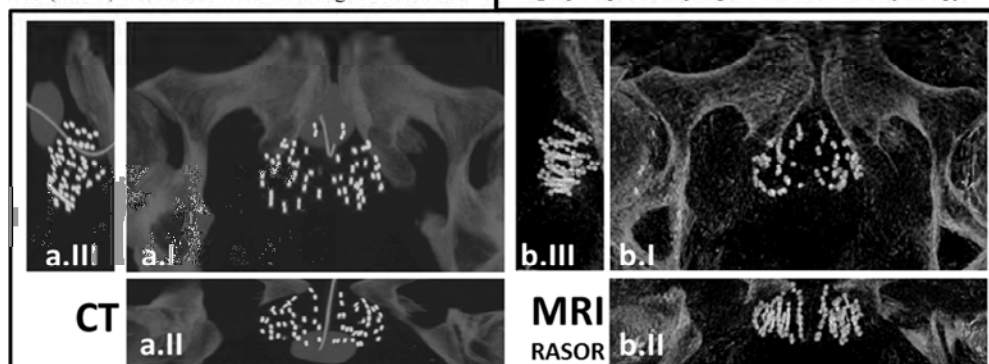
a I,II,III) Orthogonal MIP's of a 3D CT dataset, depicting seeds, bone and a urinary catheter. b I,II,III) Orthogonal MIP's of a 3D background-suppressed RASOR dataset rigidly registered to the CT data using the bone structures, also depicting both the seeds and the bone in a fluoroscopic representation.
